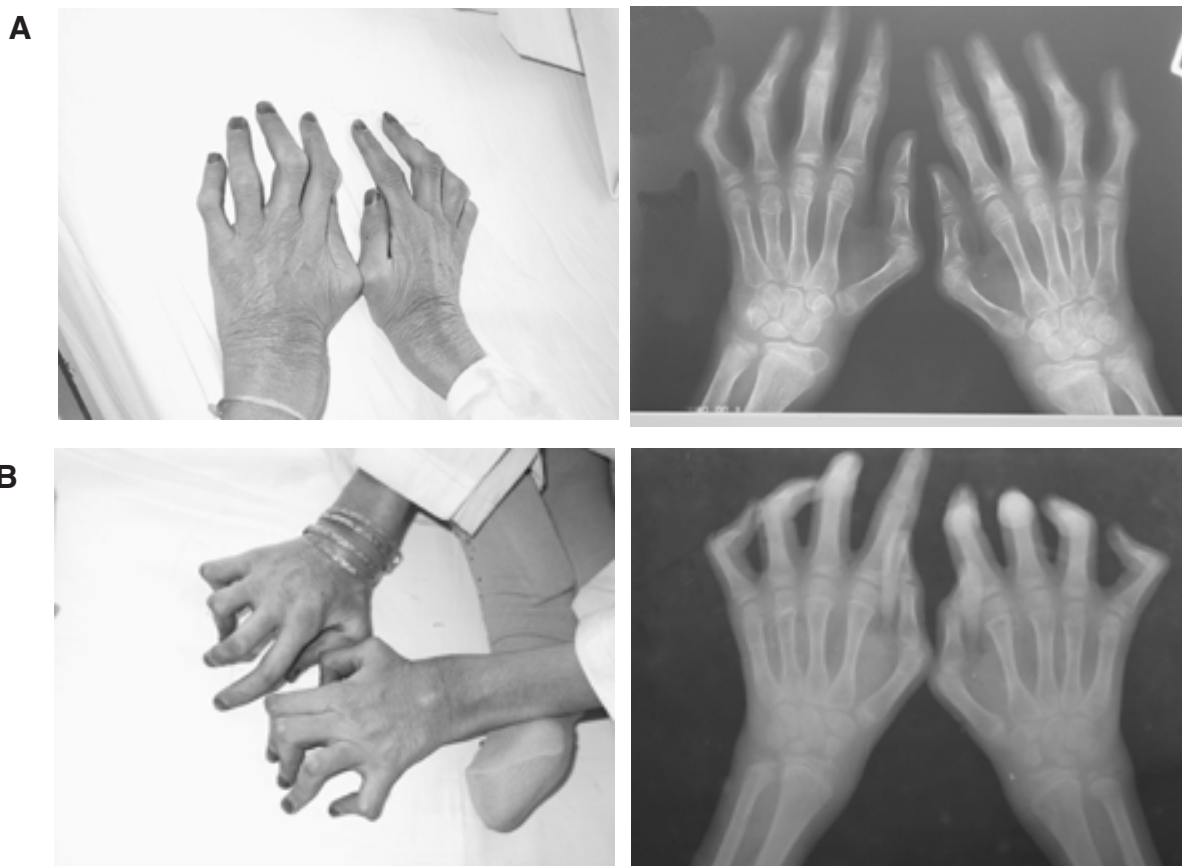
A. Case 1, with Boutonniere's deformity of most digits. Radiograph shows decreased joint space is mostly in proximal interphalangeal joints. B. Case 2 shows a synovial cyst on the left wrist. Radiograph shows bilateral first metacarpophalangeal luxation.
